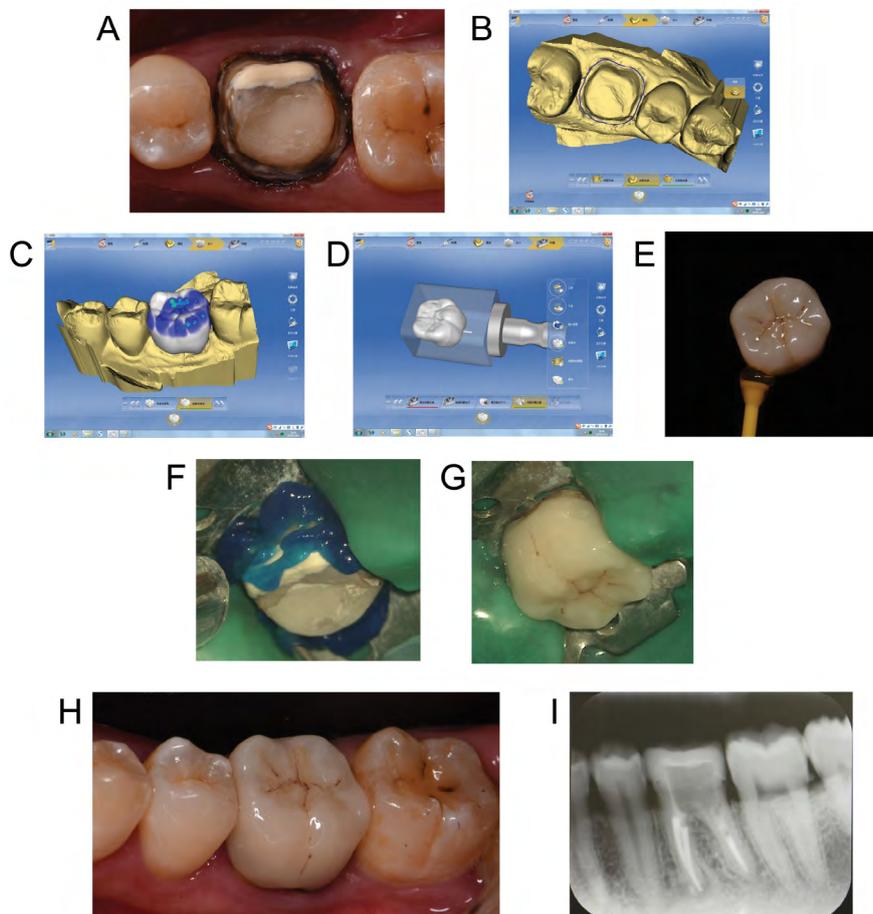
(A) Preparation of full crown of tooth #36; (B-D) The design of full crown by Cerec AC, v.4.0, Sirona Dental Systems; (E) The coronal restoration made by IPS e.max CAD lithium-disilicate ceramic (Ivoclar-Vivadent); (F) The surface of prepared tooth was etched with 37% phosphoric acid; (G) The full crown was cemented by RelyX Ultimate Clicker Adhesive Resin Cement; (H) Intraoral vision after coronal restoration; (I) A periapical radiograph of the 14-month follow-up showing healing of the mesial root radiolucent lesion and resolution of the distal root radiolucent lesion compared with preoperative radiograph.
